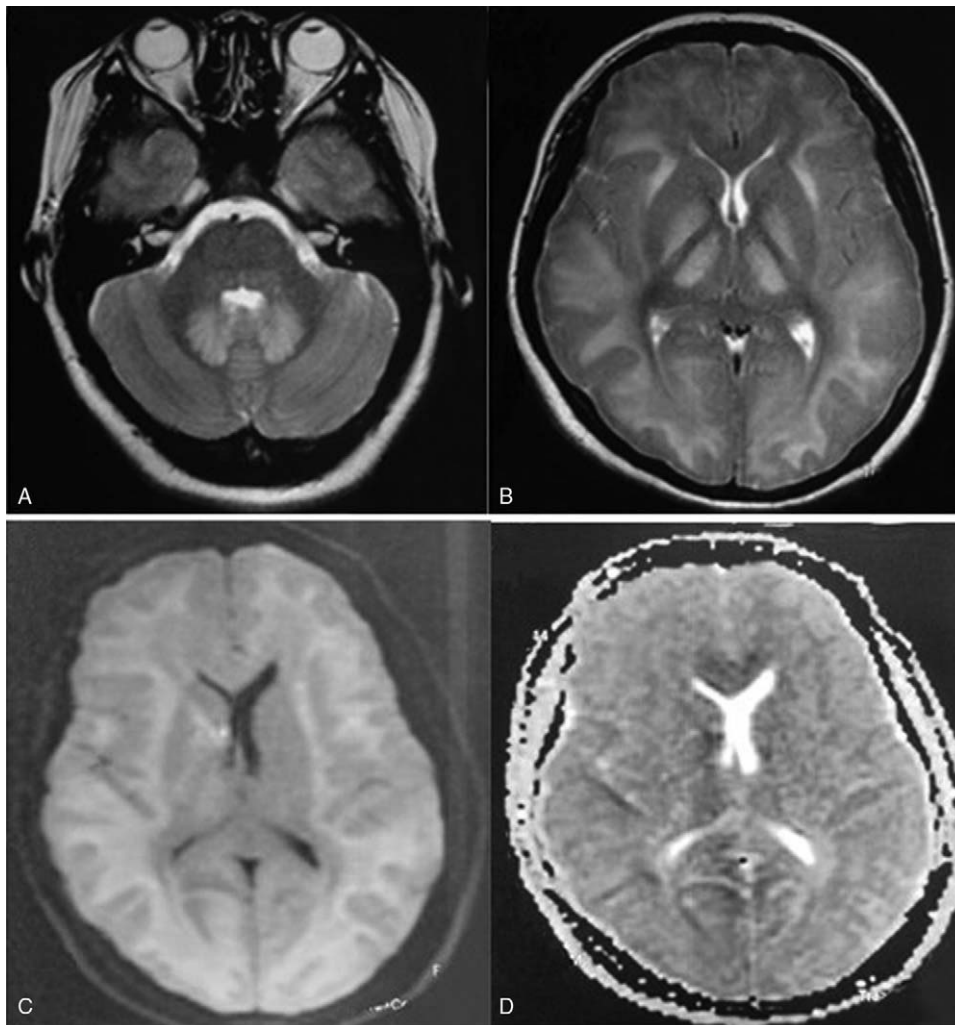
A 20-year-old female had worked in a shoe-making factory for 5 months. She was admitted to our hospital complaining of a headache. Her cranial MRI on T2WI showed symmetrical hyperintensity in the subcortical white matter, bilateral globus pallidus (B), and cerebellar dentate nuclei (A), as well as a swollen gyrus, a shallow/disappearing sulcus, and a reduced ventricle. DWI (TR 2400/TE 74) (C) and ADC (D) mapping showed hyperintensity and hypointensity, respectively, in the niduses above. After treatment with sufficient steroids and mannitol, she recovered, as seen by disappearance of clinical symptoms and reduced lesions on a follow-up cranial MRI (not shown).
